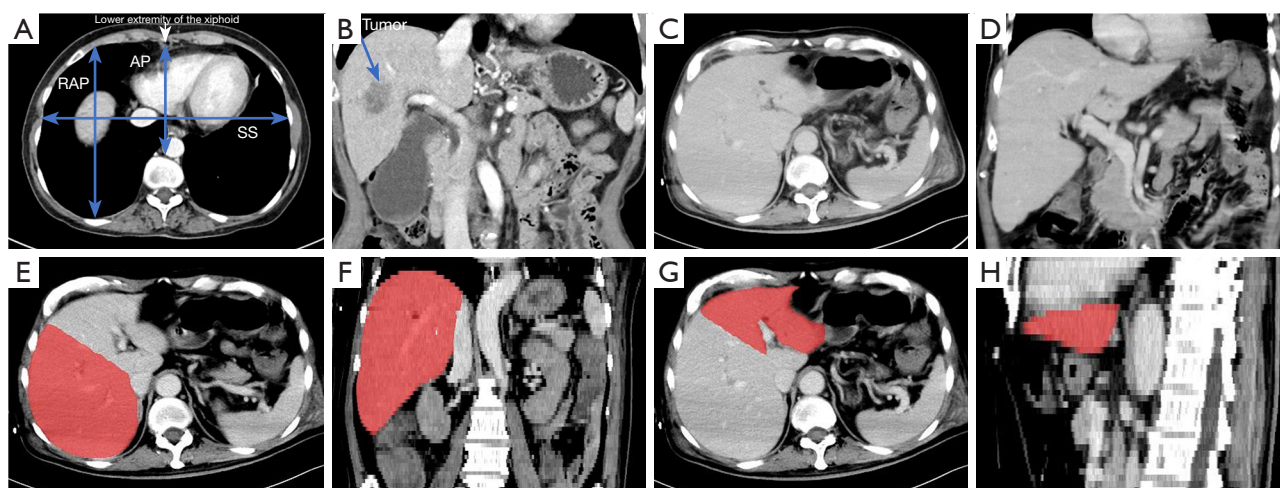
Preoperative CT scan and manual CTV of the liver. (A) Morphometric measurements based on a CT scan of the recipient. RAP: the longest right anteroposterior vertical distance between the anterior and posterior parts of ribs; AP: anteroposterior distance (lower extremity of the xiphoid process to the anterior wall of vertebra); SS: side-to-side distance (the largest intraperitoneal and horizontal distance); (B) coronal abdominal CT scan of the recipient revealed a tumor located in the right anterior lobe of the liver (blue arrow); (C,D) axial and coronal abdominal CT scan of the donor; (E,F) manual CT liver volumetry of right lobe (red); (G,H) manual CT liver volumetry of left lobe (red). CT, computed tomography; CTV, computed tomography volumetry.
